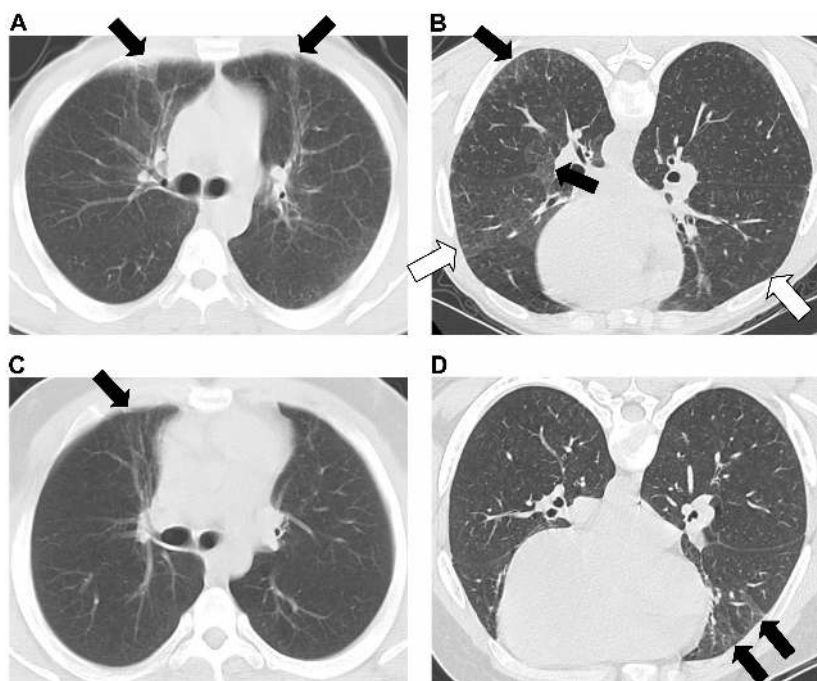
Representative computed tomography and HRCT scan images from two adult brothers with HPS-2 and interstitial lung disease. A computed tomography and HRCT scan image in the prone position (A and B, respectively) show mild bilateral ground glass opacities (arrows) and interstitial reticulations (open arrows) in subject 2 at the age of 27 years. C and D demonstrate computed tomography and prone HRCT scan images from subject 3 when he was 22 years of age. Mild ground glass opacities (arrows) are present in the right middle lobe.
